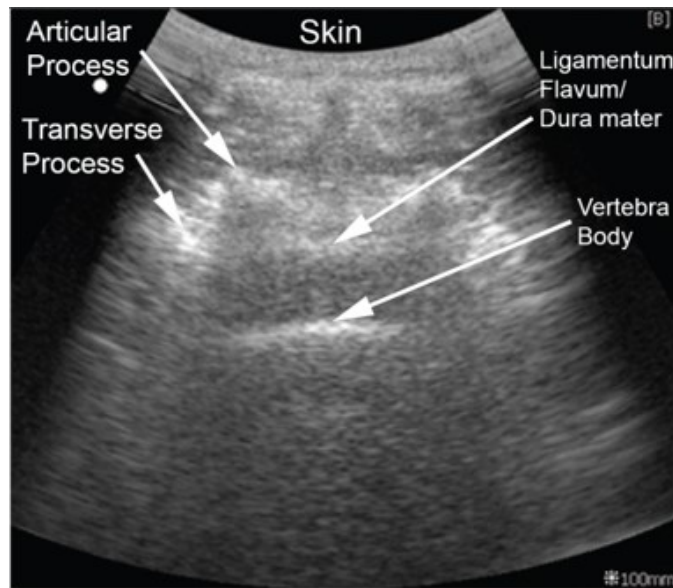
Ultrasound Image Feature of Interspinous Region in the Transverse View.
